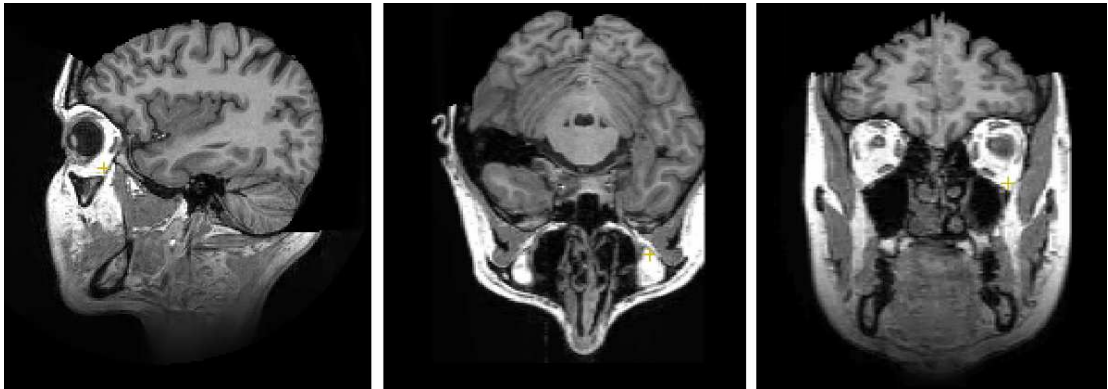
Visualisation of slices of a standard MRI dataset (MRI Head [77]). Soft tissues are clearly displayed, while bone is invisible. Further, different types of soft tissue are discriminated: for example, brain tissue appears different from the soft tissues around the face.
